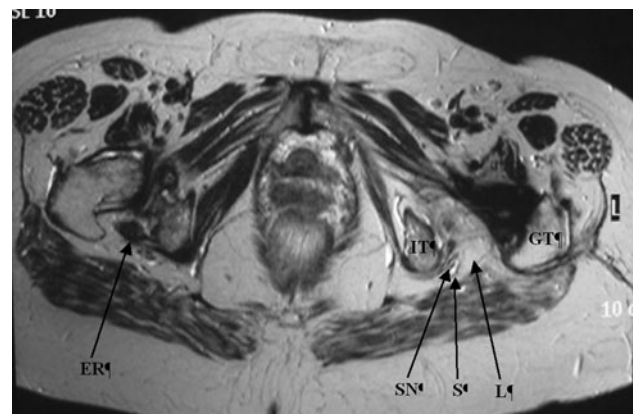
Axial T1-weighted MR image at the level of the ischial tuberosity (IT). The sciatic nerve (SN) is entrapped by a tight fibrous scar (S) and a lipoma (L) between the ischial tuberosity and the greater trochanter (GT). External rotator (quadratus femoris) tendons (ER) are absent compared to the *right side*
